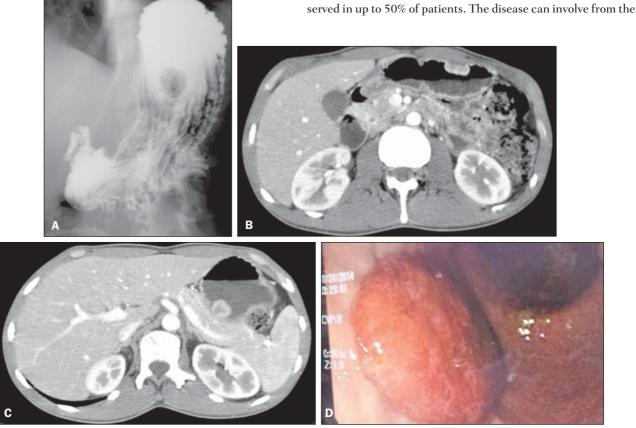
A: Radiographic image of esophagus, stomach and duodenum shows polypoid filling defect. B,C: Abdominal CT arterial phase shows subepithelial hypervascular polypoid lesions. D: High digestive endoscopy shows the corresponding reddish polypoid lesion.
